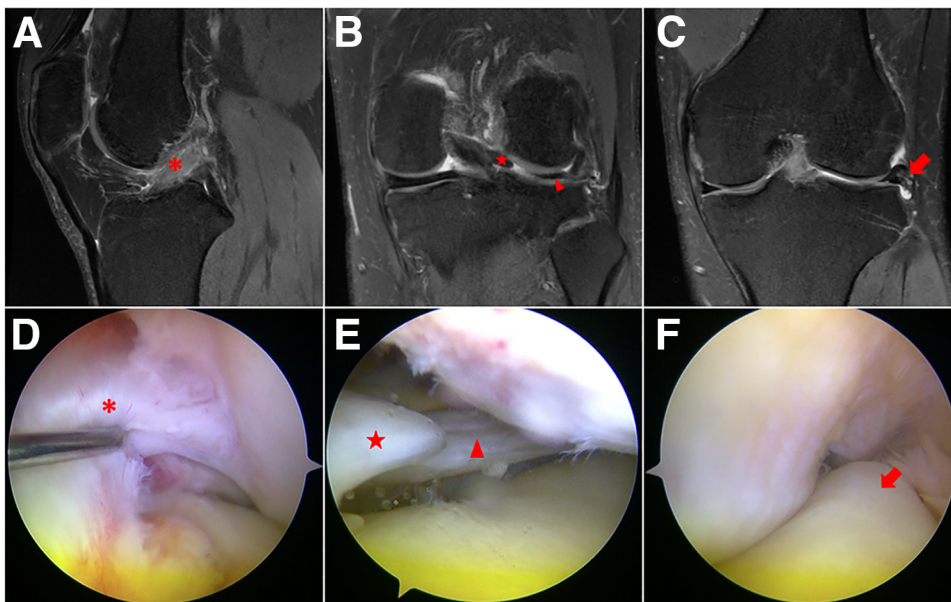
Magnetic resonance images and arthroscopic manifestation of ACL rupture and radial tear of LMPH. (A) and (D) show the remnant of the ACL (red asterisk) without normal tension, (B) and (E) present the radial tears of the LMPH (red five-pointed star indicates the broken end of LMPH adjacent to the posterior root, red triangle indicates the other end), and (C) and (F) are signs of lateral meniscus extrusion (red thick arrow). (ACL, anterior cruciate ligament; LMPH, lateral meniscus posterior horn.)
